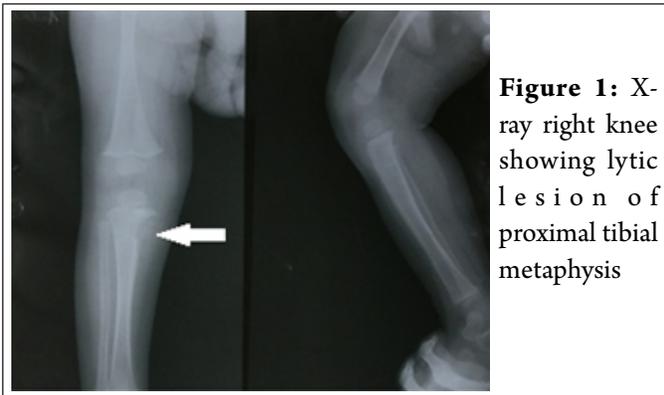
X-ray right knee showing lytic lesion of proximal tibial metaphysis
